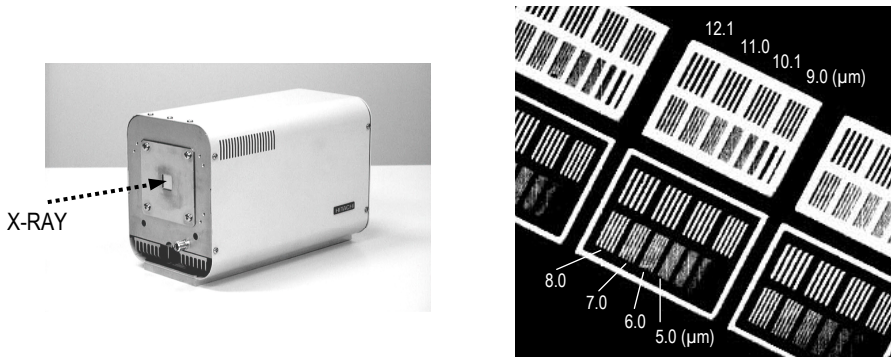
Photograph of the X-ray SATICON camera (left) and zoomed image of the central area of the 5- $\mu$ m-thick chart. Numerical values show bar widths (right).
